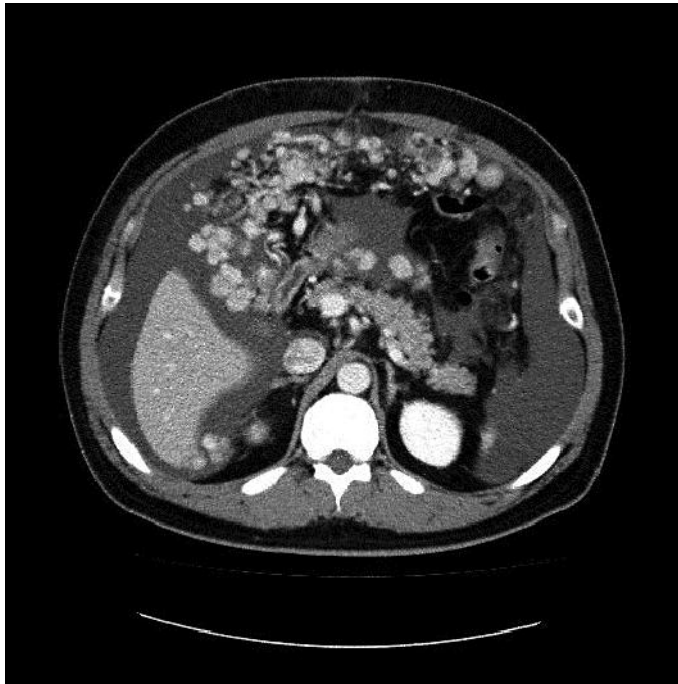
A CT scan of the abdomen shows multiple nodules in the omentum, with a large amount of ascites.
